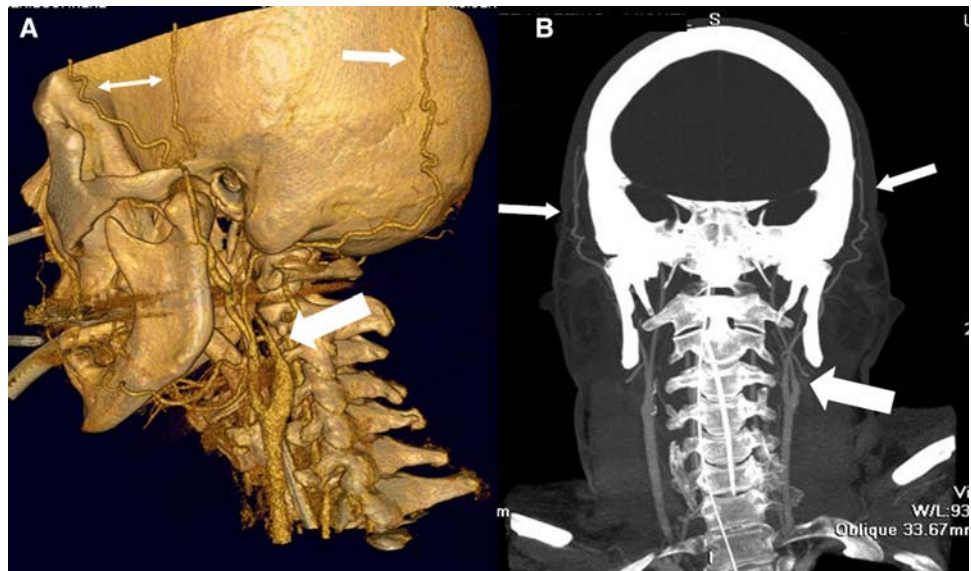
CTA revealing the lack of blood flow in the brain. 3D-image reconstruction. *Fine arrows* point to the superficial temporal artery, a branch of the external carotid artery. *Thick arrow* indicates the site of craniectomy
